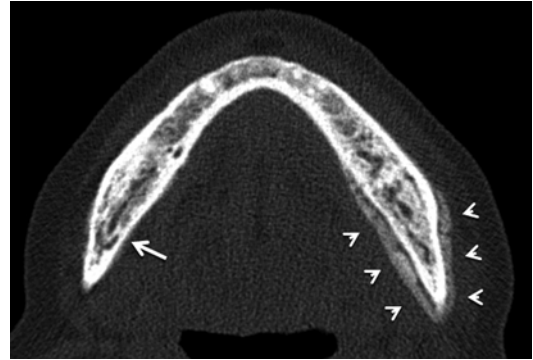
Multislice computed tomography (MSCT). Mandible affected by BRONJ. Extended left perimandibular periosteal reaction (*arrowheads*). Osteosclerosis with disorganized irregular medullary trabeculation throughout the complete mandible. Prominent mandibular canal can be seen at the right mandible (*large arrow*)
